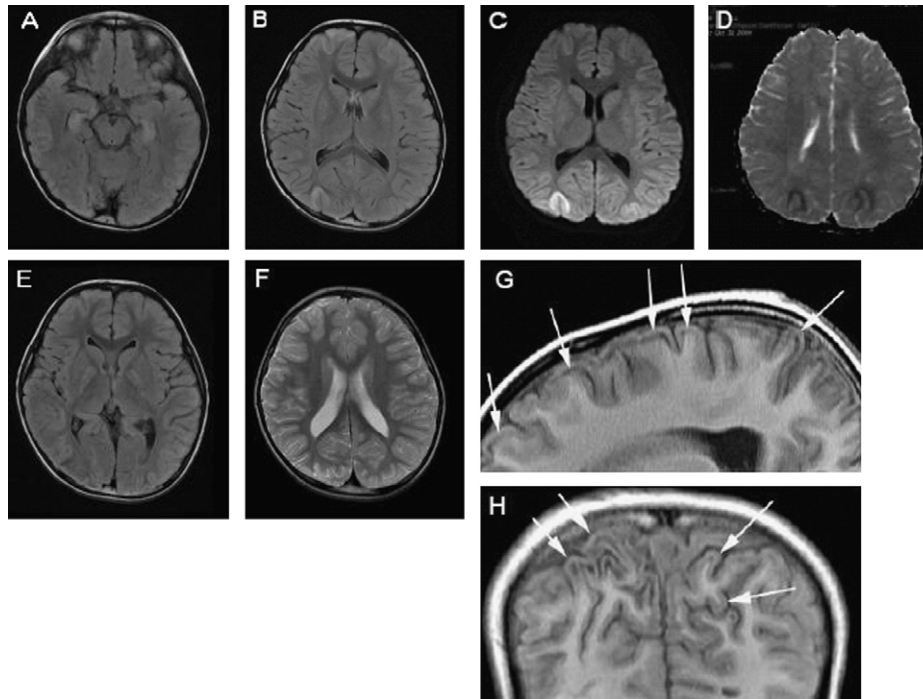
Brain MRI at day 6 (A to D), day 17 (E), and day 122 (F to H) of illness. (A and B) Fluid-attenuation inversion recovery (FLAIR) images showing high signal intensity in the bilateral hippocampus, right occipital, and right frontal deep layers of cerebral cortex. (C and D) Diffusion-weighted image (DWI, C) shows high intensity at the occipital lesions with right-sided predominance. Decreased diffusivity is noted in these areas on the ADC map (D). (E) Symmetrical, high intensity lesions on FLAIR imaging appeared in the globus pallidus during the recovery phase of delayed encephalopathy. (F to H) Lesions in the deep cortical layers became prominent on follow-up MRI, with high intensity on T2-weighted images (F) and low intensity on T1-weighted images (G and H, arrows).
